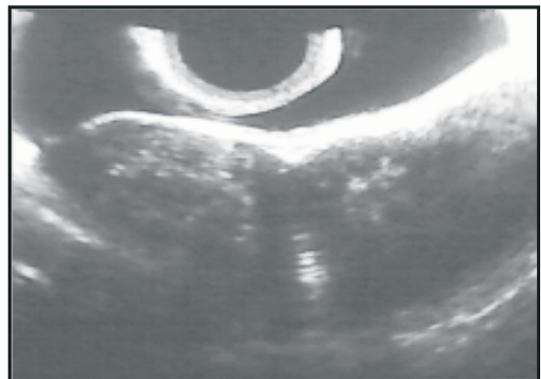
Trasvaginal ultrasound shows adenomyotic changes in both uterine horns(case 1)
